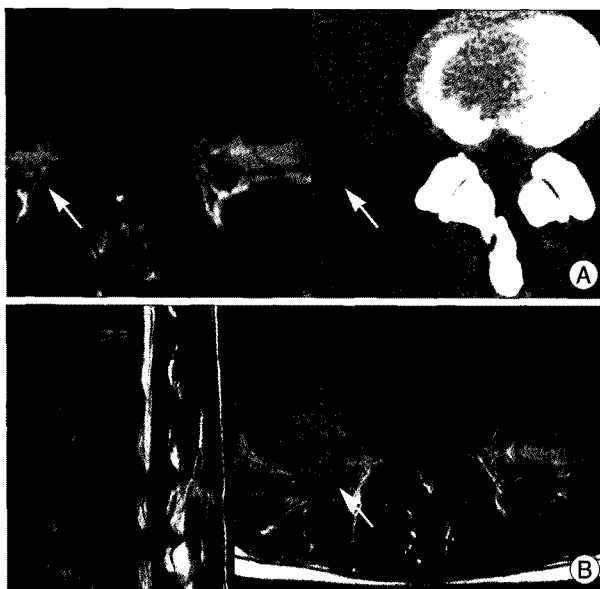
A 35-year-old female patient (patient 5) presented with a one-year history of severe lower back pain and right leg pain. Preoperative axial T1-weighted magnetic resonance imaging (MRI) and computed tomography (CT) scan show an extruded disc herniation on the right side at the L4-5 level (A). Note the posterior extension of the ascending colon on the MRI and CT scan (arrow). T2-weighted MRI 9 days after PELD shows a large right psoas abscess (arrow) and secondary spondylodiscitis (SD) at the L4-5 level (B). *E. coli* was cultured from the psoas abscess.
